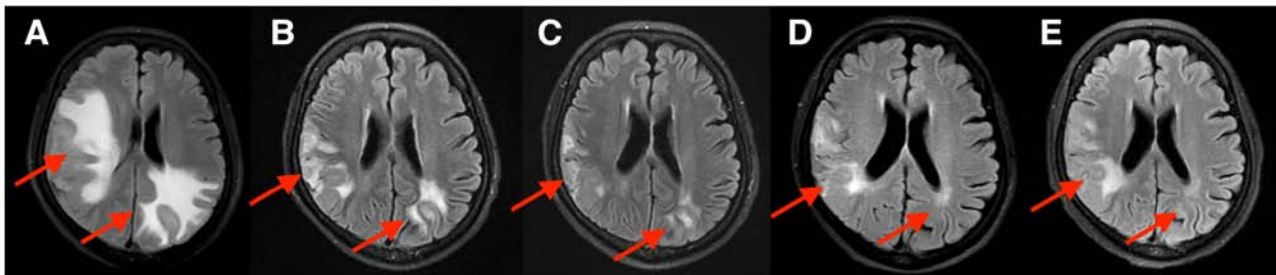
Brain MRIs of response in peritumoral brain edema to apatinib + trastuzumab + albumin-bound paclitaxel. (A) Prior to combination treatment (T2-weighted longTR FLAIR), (B) after 2 cycles of combination treatment (T2-weighted FLAIR), (C) after 4 cycles of combination treatment (T2-weighted FLAIR), (D) after 6 cycles of combination treatment (T2-weighted longTR FLAIR) and (E) after 8 cycles of combination treatment (T2-weighted FLAIR). The white areas indicated by arrows are peritumoral brain edema. MRI, magnetic resonance imaging. FLAIR, fluid attenuated inversion recovery; longTR, long repetition time.
